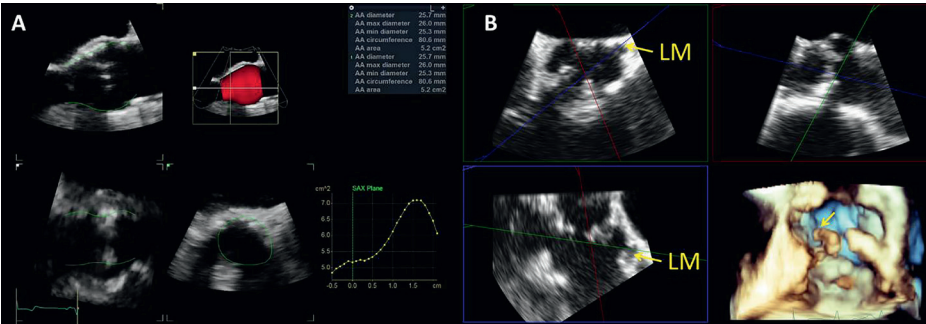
3-dimensional transesophageal echocardiography (3D-TEE) in TAVR planning. (A) Automated analysis of the aortic root (AVQ software, GE, Horten, Norway) allows quick alignment of the orthogonal planes across the aortic annulus (AA) and accurate sizing. (B) Multiplanar 3D reconstruction of the aortic root to measure the distance between the main (LM) coronary artery from the aortic annulus (yellow arrows). At the same time the presence of bulky calcified cusps that may obstruct the coronary ostia can be appreciated, particularly in the 3D reconstruction.
